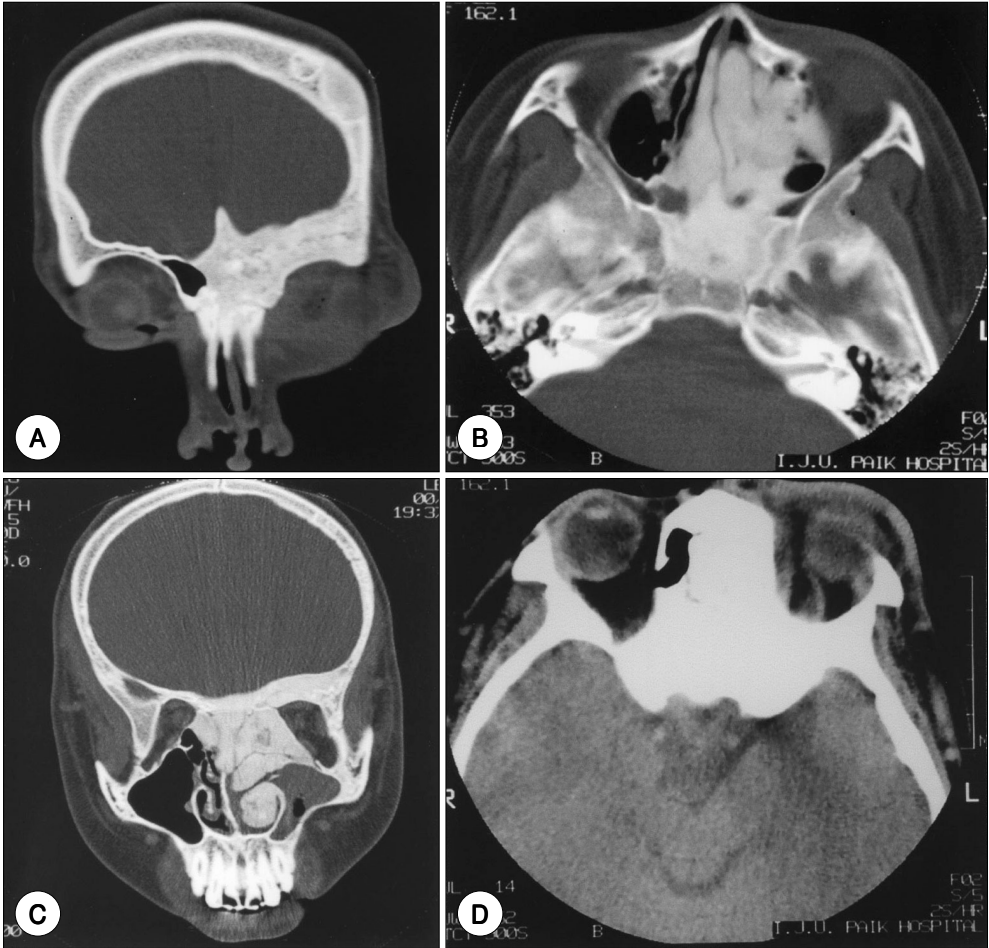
Coronal (A), (C) and axial (B), (D) CT scan of paranasal sinus : The mass is extended to skull base, bilateral frontal, ethmoid, sphenoid sinuses, left maxillary bone, septum, left middle and inferior turbinate (ground glass appearance). D : shows left periorbital swelling.
